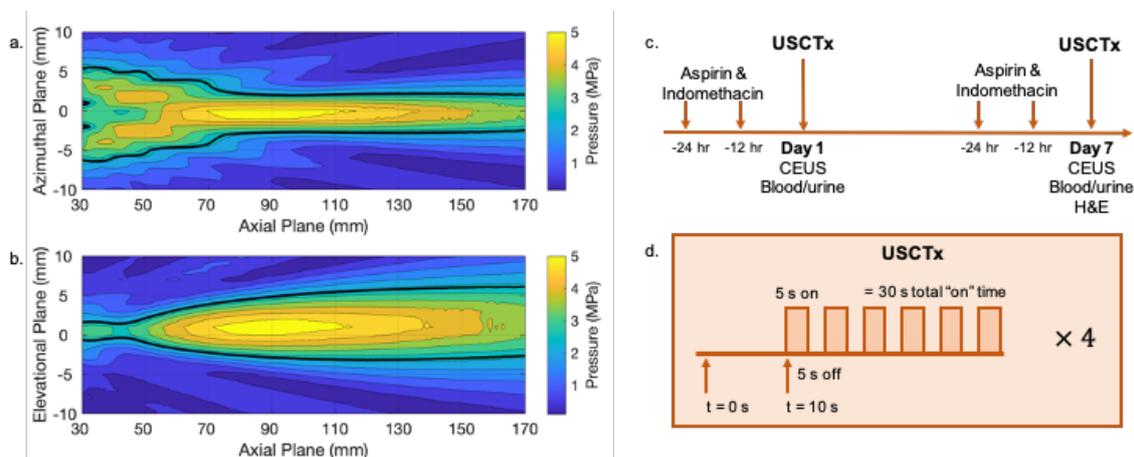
Measured ultrasound field in water from the S5-1 phased array probe used for USCTx (a-b). Overview of experimental study, including timeline (c) and treatment protocol (d).
